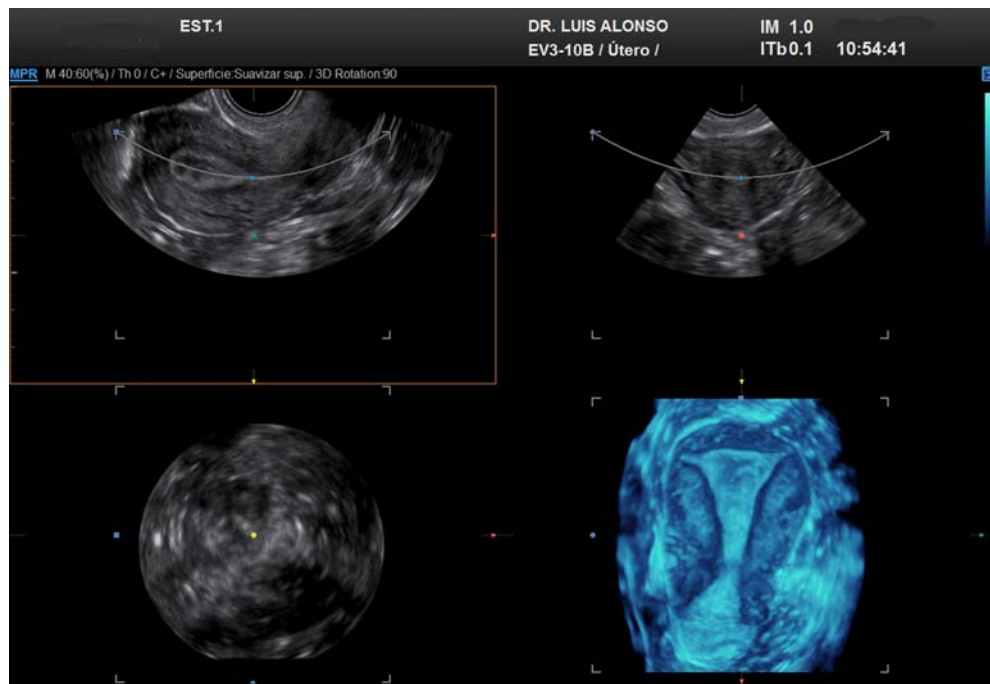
Three-dimensional ultrasound for uterine evaluation.
